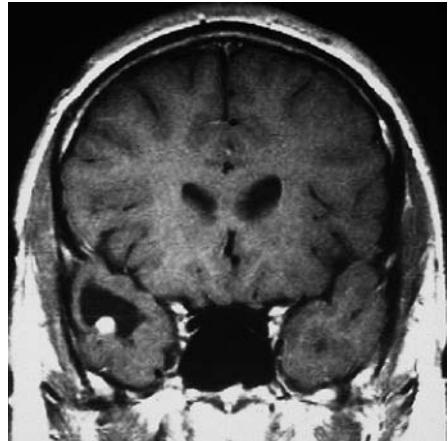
MRI of a cystic ganglioglioma in the left temporal lobe with an intramural nodule.
